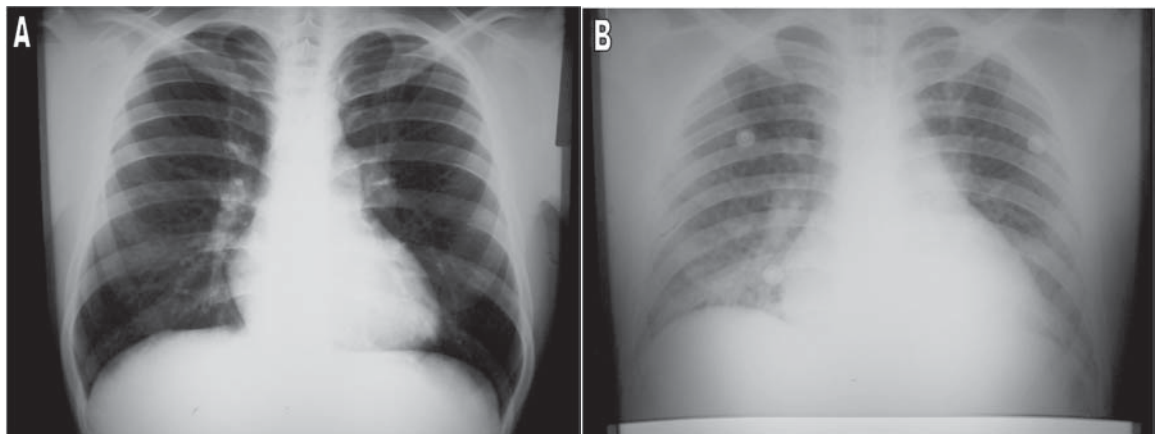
A) Initial chest X-ray apparently normal; B) Chest X-ray upon admission to ICU, showing signs of congestion and pulmonary hypertension
